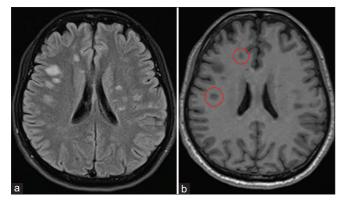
Magnetic resonance imaging (MRI) showed the evidences of multiple sclerosis. (a) Brain MRI (fluid-attenuated inversion recovery T2-weighted) showed multiple hyperintense nodules in bilateral cerebral white matter. (b) Brain MRI (T1 weighted) showed some hypointense nodules (red circles) in the cerebral white matter
